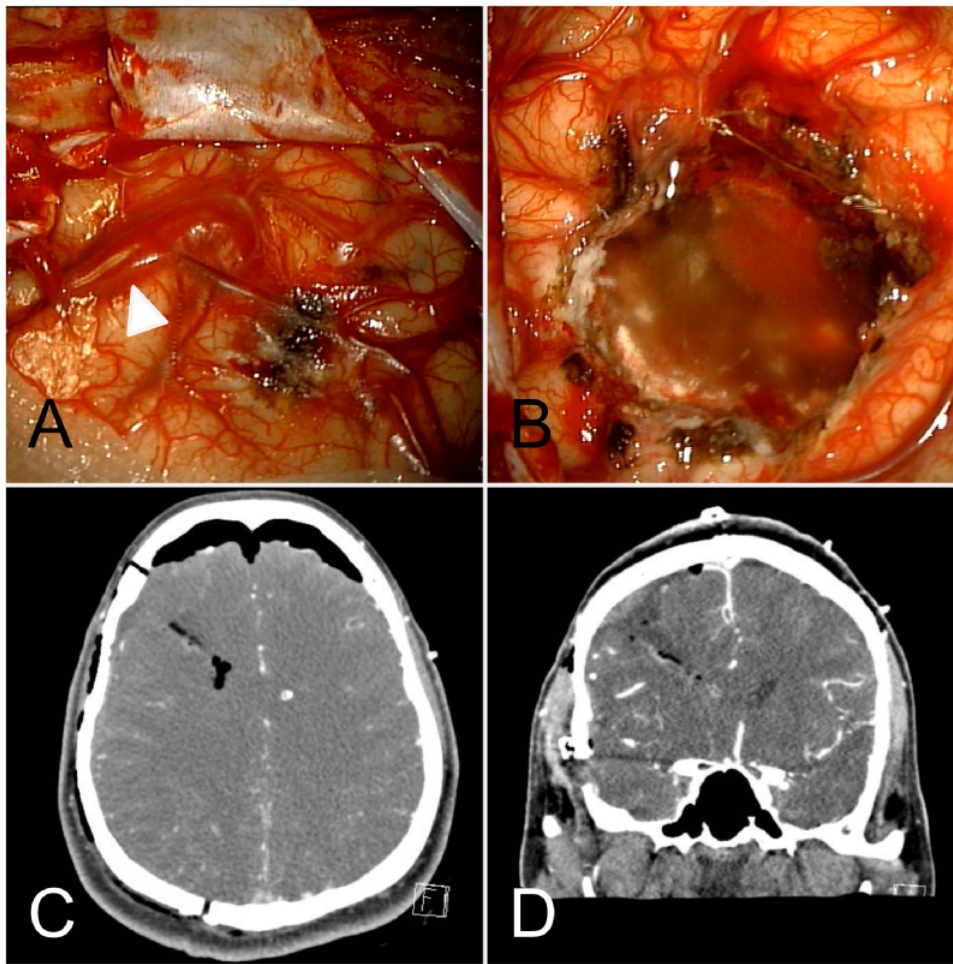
Intraoperative and postoperative imaging. Intraoperative images demonstrate the AVM (A) with an arterIALIZED draining vein (white arrowhead) and successful resection with the cavity filled with saline (B). Postoperative CTa axial (C) and coronal (D) reconstructions demonstrate no residual AVM or complicating features of surgery. AVM, arteriovenous malformation; CTa, computed tomography angiography.
